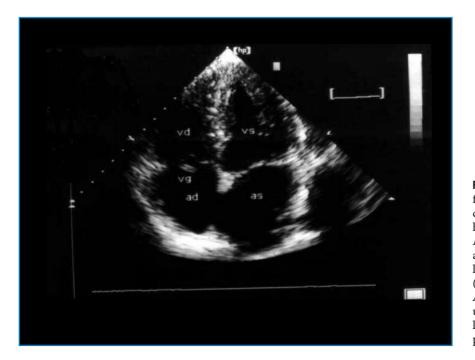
Echocardiographic finding of *Candida* endocarditis in an intravenous heroin user suffering from AIDS. A vegetation (*vg*) is attached to the anterior leaflet of the tricuspid valve (apical four-chamber view). *AD*, right atrium; *AS*, left atrium; *VD*, right ventricle; *VS*, left ventricle. (From [1] with permission from Elsevier)
